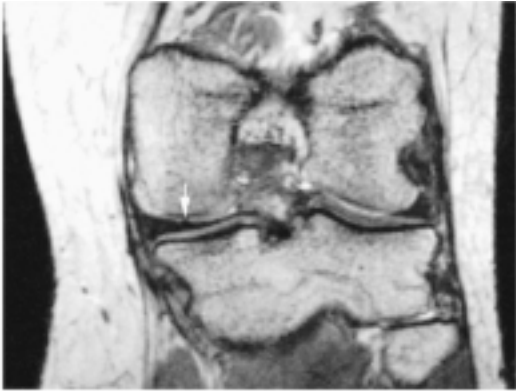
Coronal gradient-echo MRI image. Small micro-metal artefacts in the meniscus or cartilage, showing the previous site of suture (arrow).
